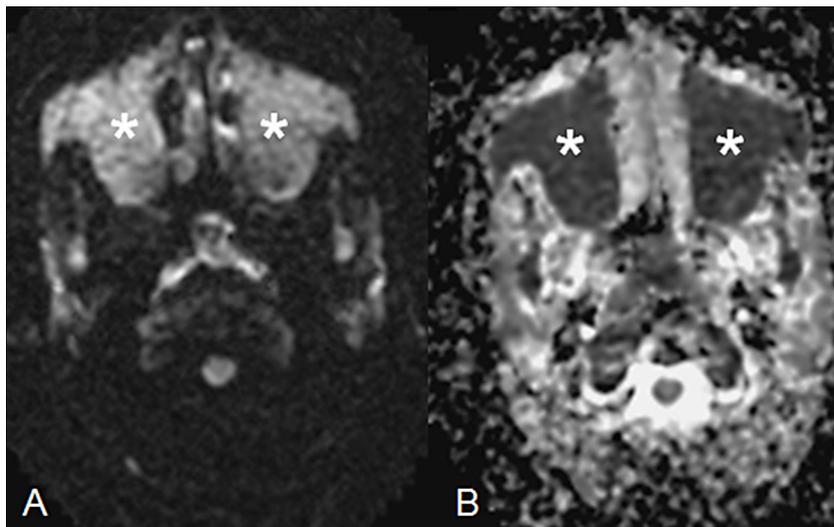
DWI with trace image (A) and corresponding ADC map (B) shows diffusion restriction within the masses (asterisk) of both maxillary sinuses.
